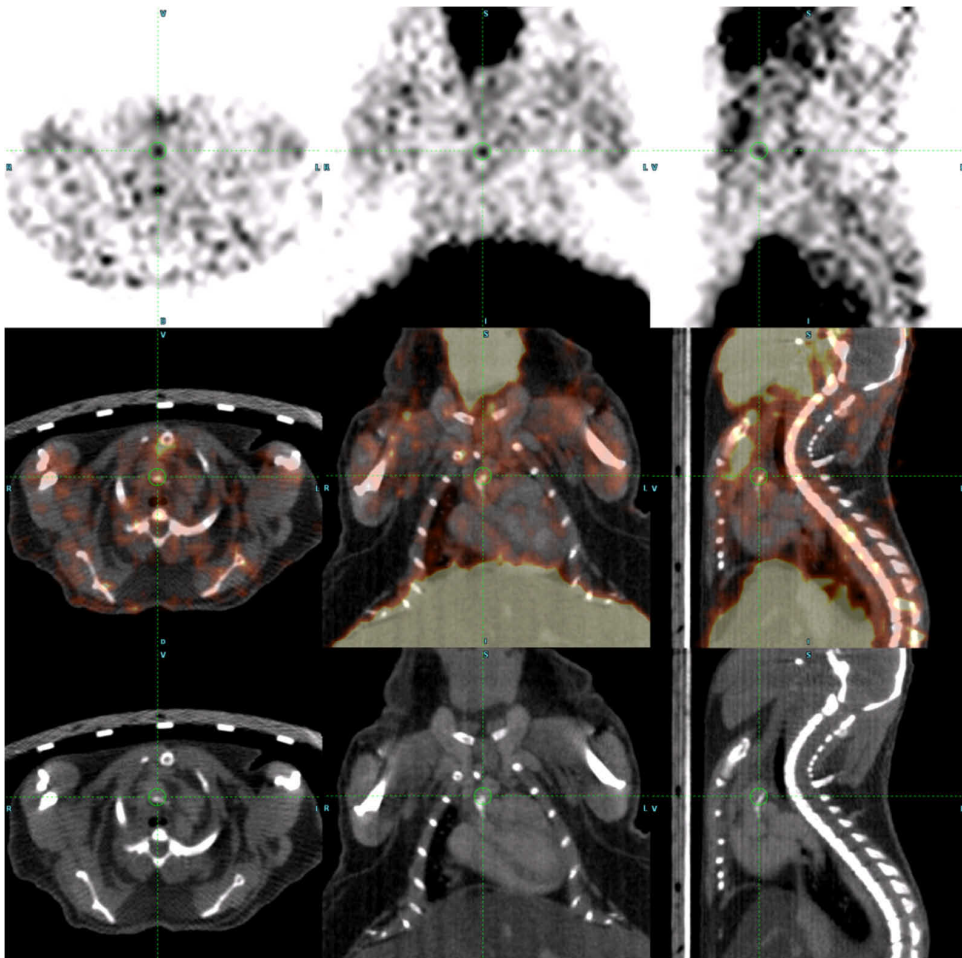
^{18}F -galacto-RGD co-localises with calcified advanced plaque. a) PET image, b) co-registered image and c) CT image
